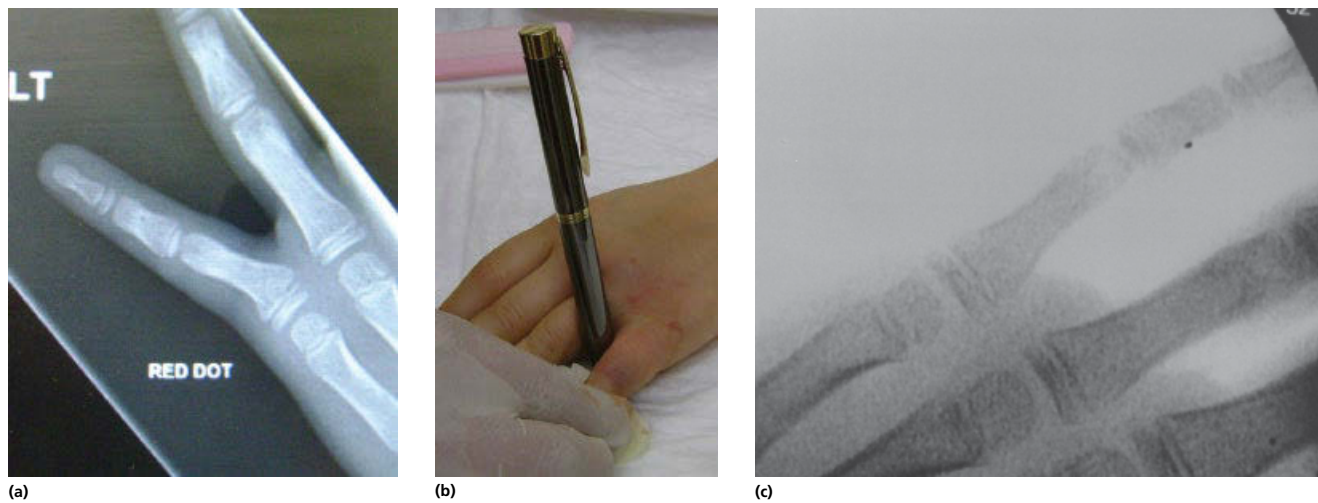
Example of Salter–Harris II. (a) Prereduction radiograph. (b) Mode of reduction. (c) Postreduction radiograph.
